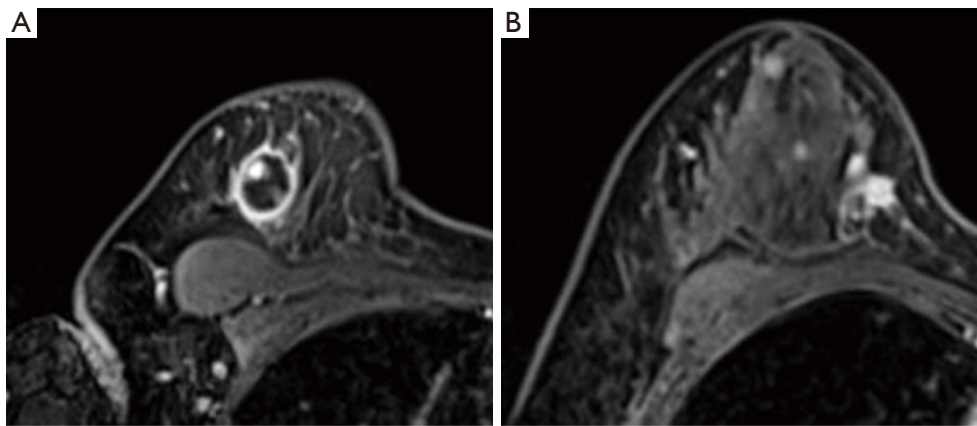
Pretreatment magnetic resonance image. There is a high-intensity tumor with a central low-intensity area in the right upper-outer quadrant (A). In the right lower quadrant, there is a tumor with irregular margins (B).
